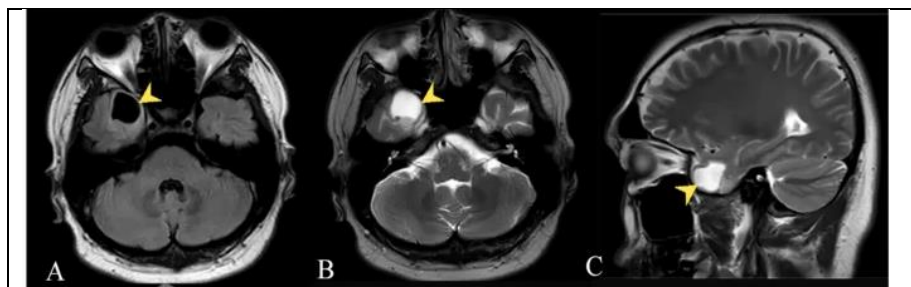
A B C: A lesion in the right temporal pole with hyperintensity on both T1- and T2-weighted images was discovered on pre-operative MRI.
